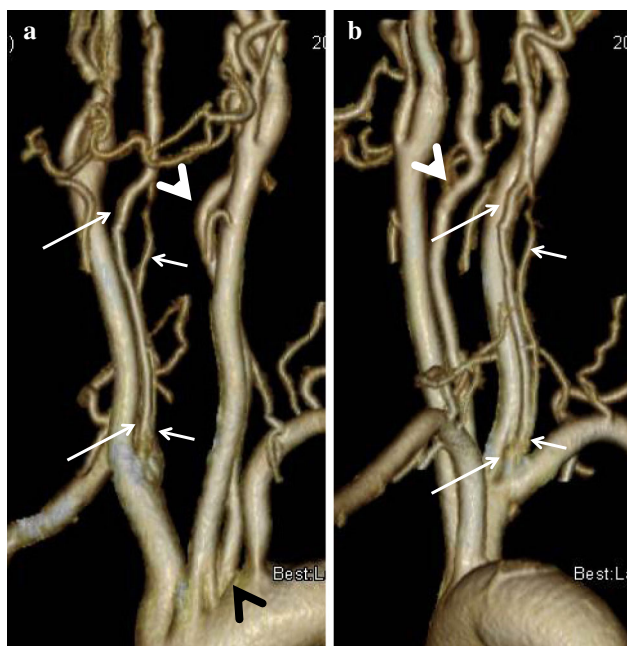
Computed tomography angiography of the neck region. Left anterior oblique (a) and slightly left posterior oblique (b) projections of volume-rendering images show two arteries arising from the extreme proximal right subclavian artery (long and short arrows). The fusion of the arteries at the level of the carotid bifurcation indicates the duplicate origin of the right vertebral artery (VA). The left VA arises directly from the aortic arch and enters the transverse foramen at the level of the carotid bifurcation (arrowheads)
